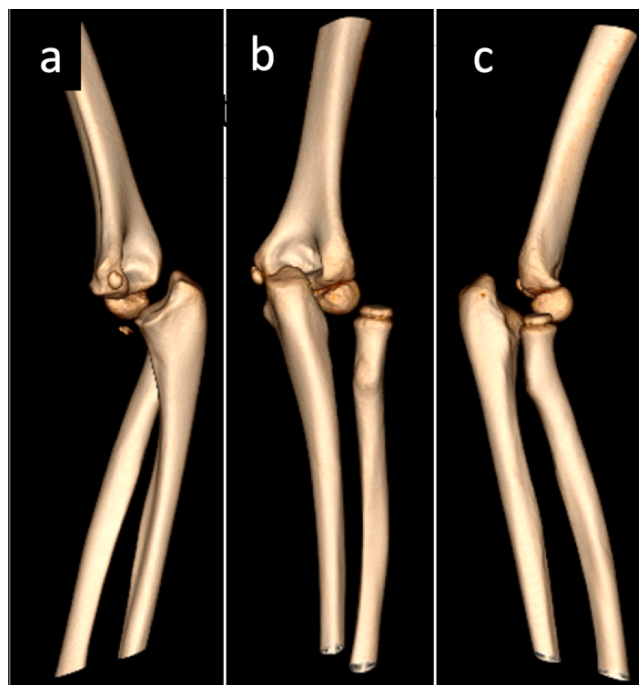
to 2C. Lateral (2A), Anteroposterior (2B), and Oblique (2C) views of the 3D reconstruction from computed tomography demonstrating divergent elbow injury with posterolateral radial head dislocation, posterior elbow dislocation, and Type 1 coronoid process fracture.
